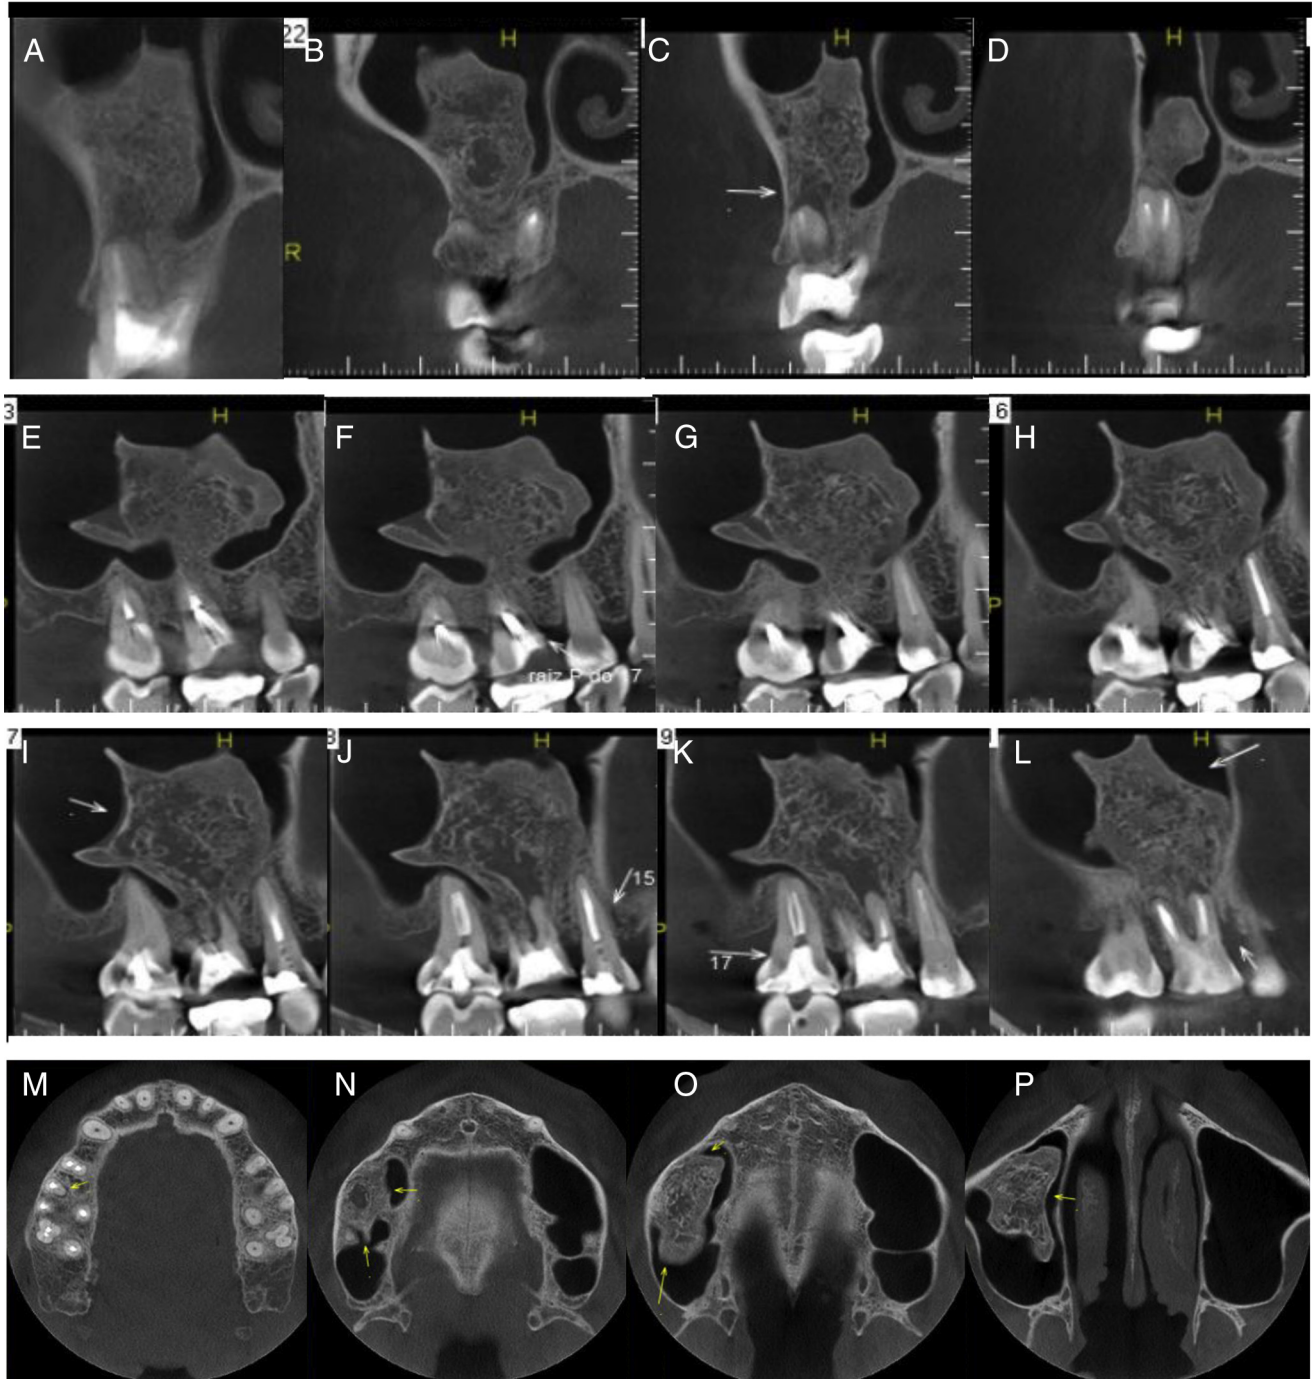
(A–P) CBCT scan shows a large area of apparent cancellous bone surrounded by a thin extension of cortical bone into the right MS.
